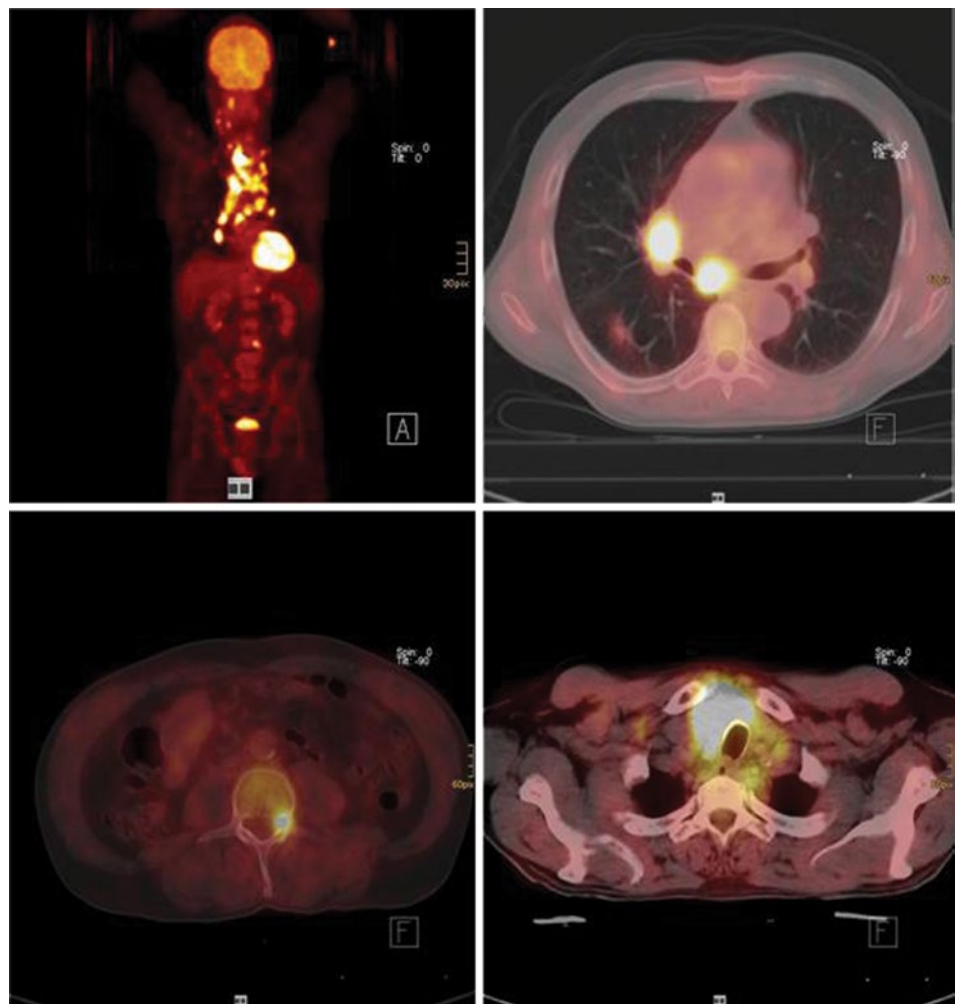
^{18}F -FDG PET-CT of a 53-year-old man with a fast growing thyroid mass, US-FNAB indicated dedifferentiated thyroid cancer. ^{18}F MIP and transaxial fused images show the extent of disease with additional multiple lymph node metastases, lung and bone metastases. The patient died 3 months after diagnosis despite systemic chemotherapy because of progressive tumour disease
